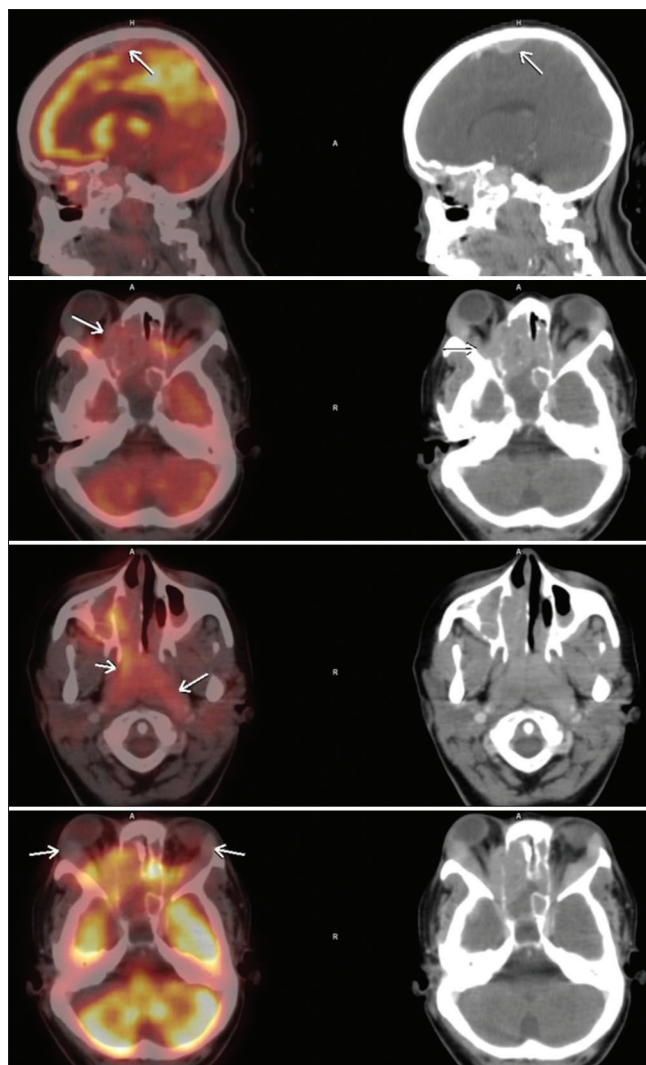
Positron emission tomography/computed tomography images of head and neck showing fluorodeoxyglucose-avid dural deposit in the high parietal region and ill-defined soft-tissue mass involving bilateral nasal cavity, ethmoid sphenoid, and maxillary sinuses with non-fluorodeoxyglucose-avid soft-tissue deposits in bilateral lacrimal glands
